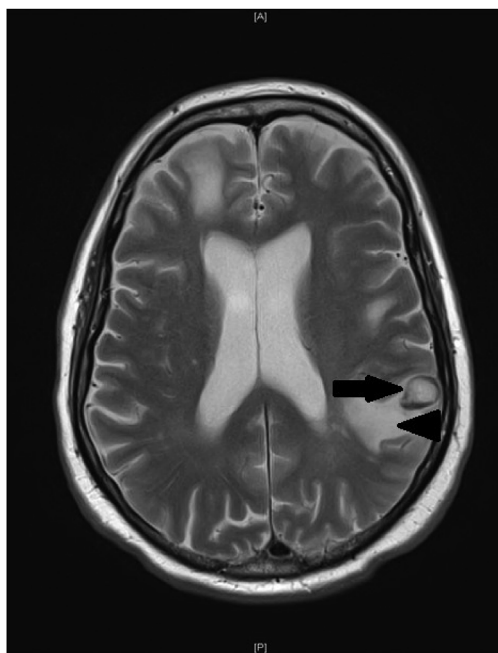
MRI scan T2 weighted (axial) with 14mm rim-enhancing left parieto-temporal lesion (arrow) and perilesional edema (arrowhead).
